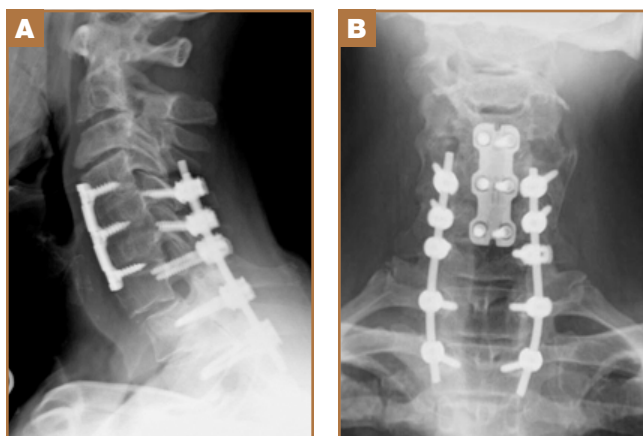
(A) Lateral and (B) anteroposterior radiographs of cervical spine 18 months after C5-T2 posterior fusion with caudal extension of the fusion construct.
